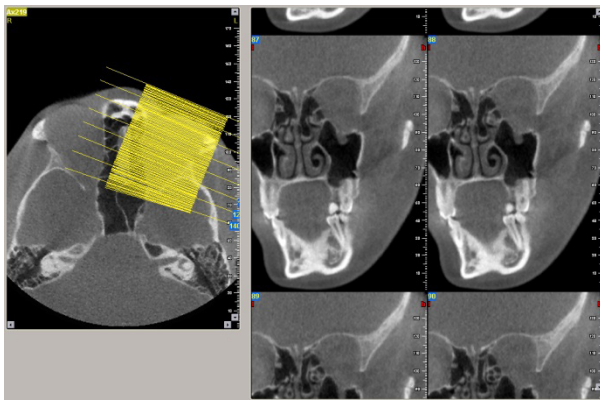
CBCT oblique coronal extracted sections.
